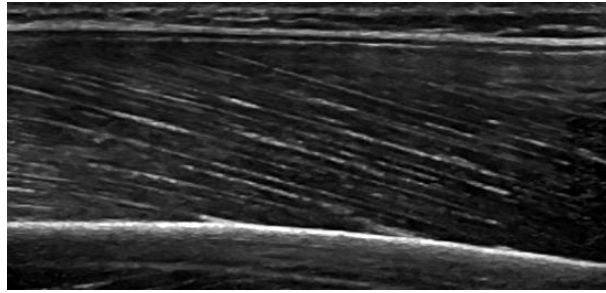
Healthy musculoskeletal ultrasound image (triceps ultrasound image).
